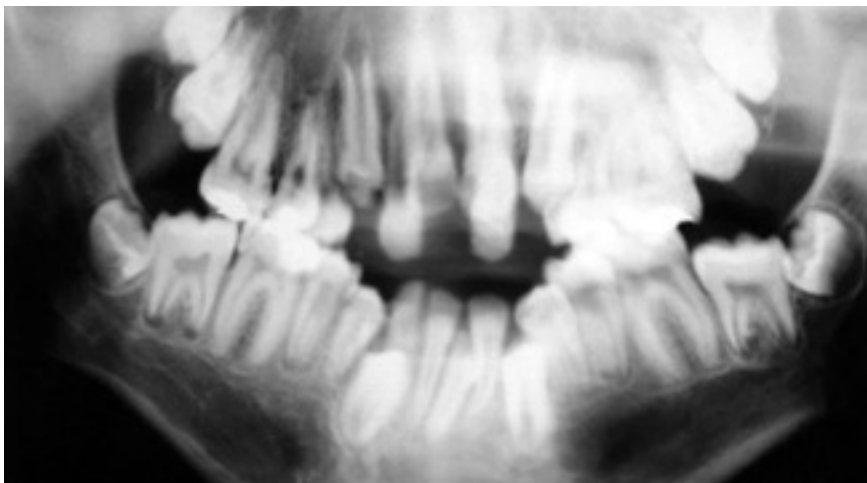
Panoramic radiography of a male case of Crouzon syndrome.
